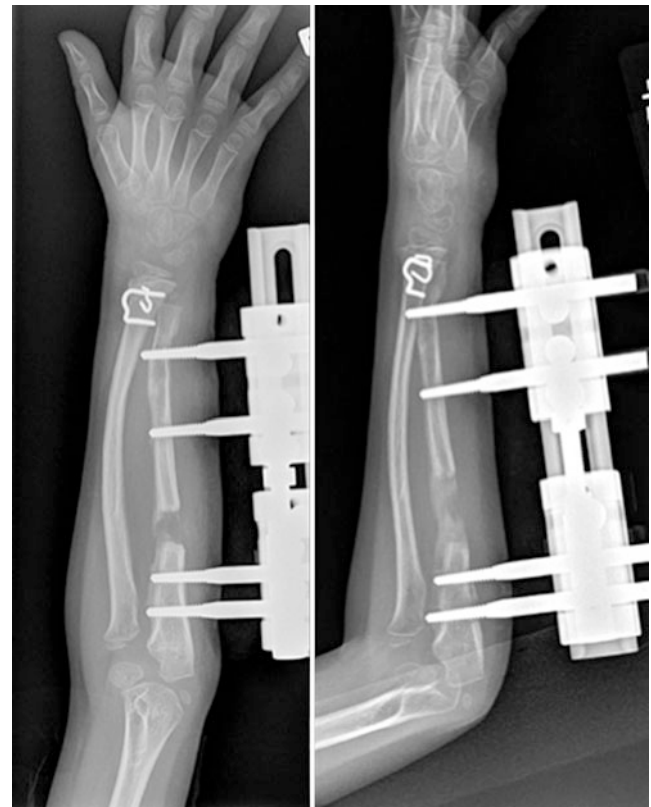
Case 1. Postoperative X-rays at 3 weeks (*left*) and 6 weeks (*right*): a distal radial closing wedge osteotomy to correct the increased tilt was fixed with two staples. The ulnar bowing was corrected acutely. The ulna was lengthened through this osteotomy. The ulnar head was transported distally
